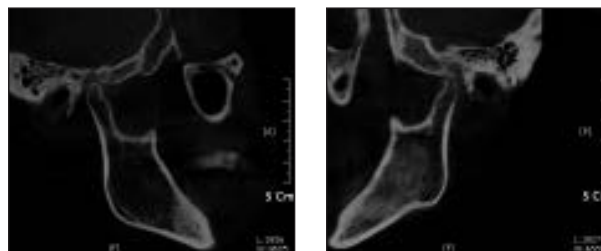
Computed tomography of the TMJs. Sagittal view of the TMJs showing slight osteophyte formation on both TMJ condyles.
